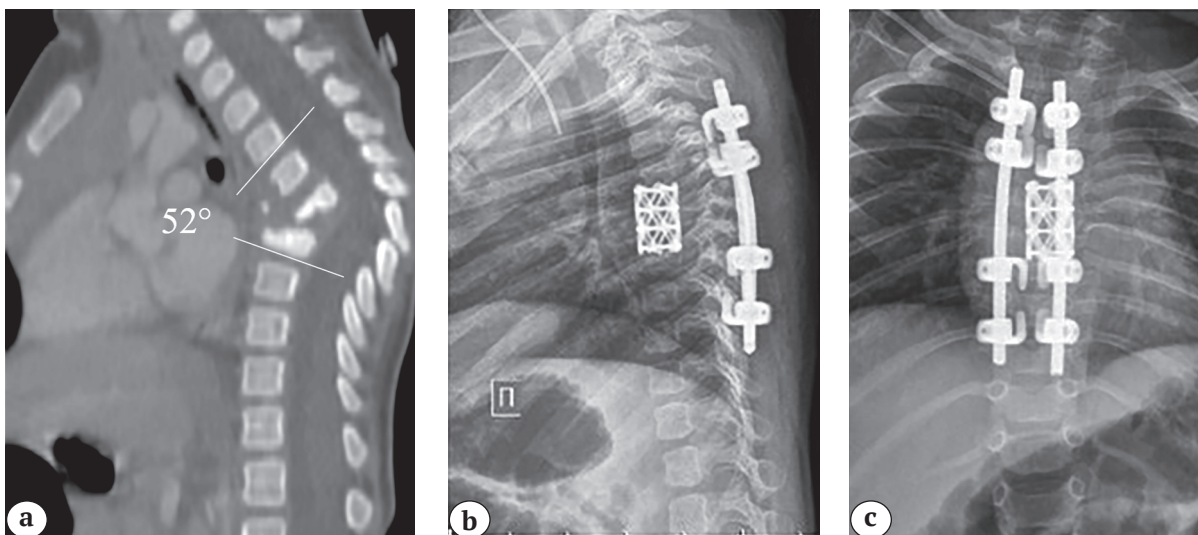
Infant, 8 months old, the effects of neonatal sepsis with lesion of Th5-Th7 vertebrae: a — CT scan, sagittal view, kyphosis is 52° combined with subtotal destruction of Th5-Th7 vertebrae; b, c — postoperation X-rays
